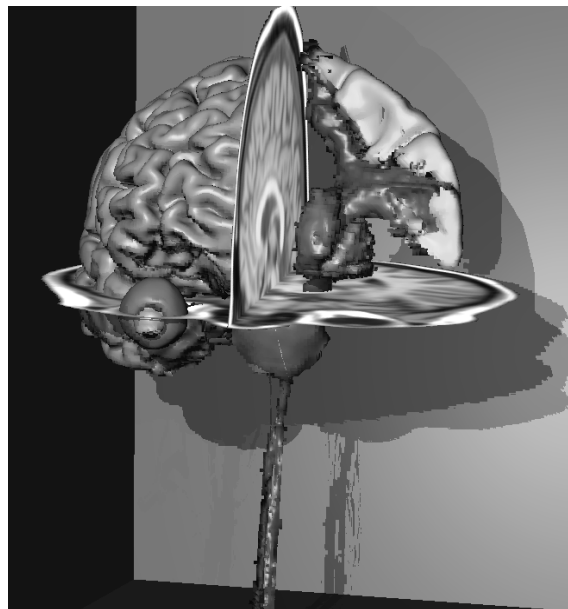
3D image of a brain from MRI. Original intensity values are mapped onto the cut planes.
